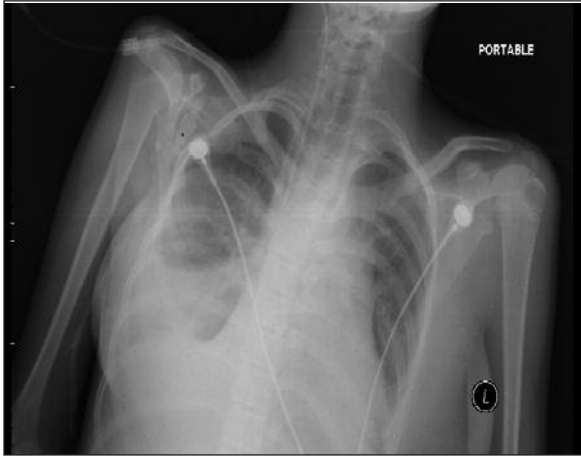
Postoperative radiography showing pneumonia and pericardial effusion.
